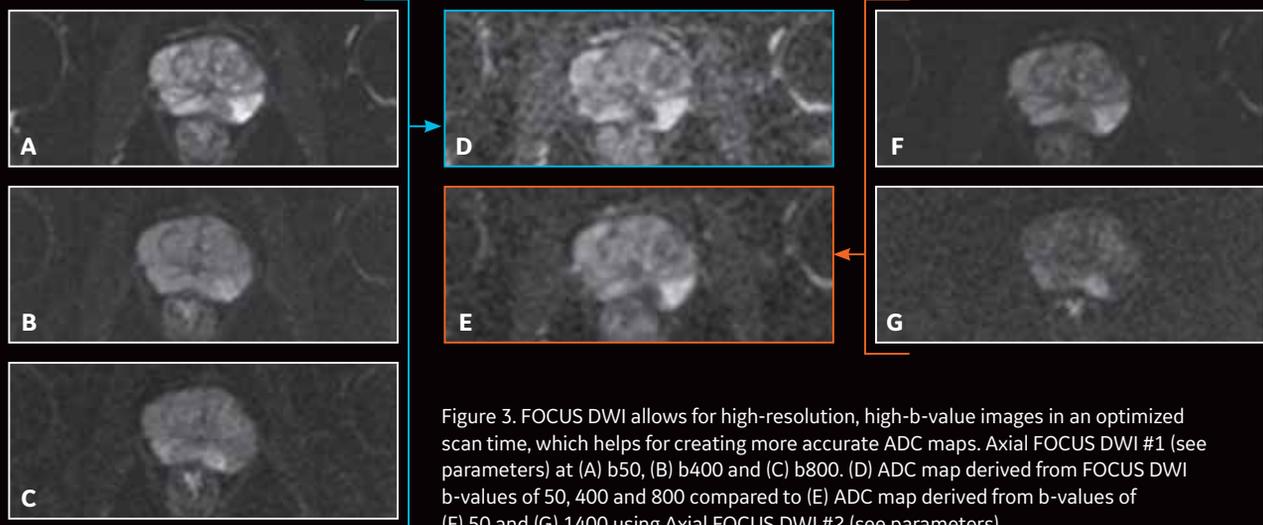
FOCUS DWI allows for high-resolution, high-b-value images in an optimized scan time, which helps for creating more accurate ADC maps. Axial FOCUS DWI #1 (see parameters) at (A) b50, (B) b400 and (C) b800. (D) ADC map derived from FOCUS DWI b-values of 50, 400 and 800 compared to (E) ADC map derived from b-values of (F) 50 and (G) 1400 using Axial FOCUS DWI #2 (see parameters).
